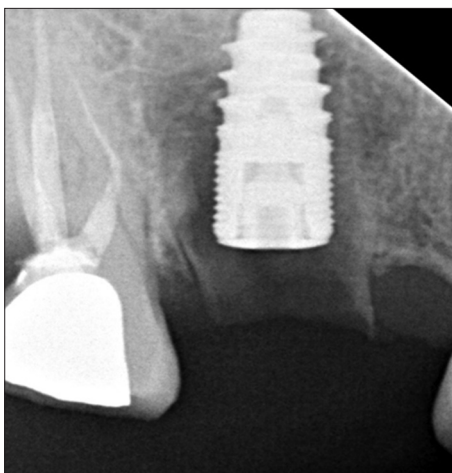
Periapical radiograph showing the implant in place and the socket shield raising above the crest of the ridge
